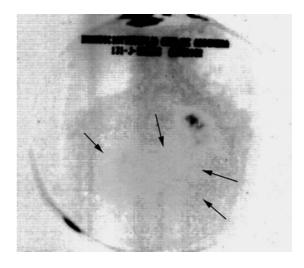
Immunoscintigraphy with IMACIS 1 anterior view shows increased accumulation of activity under the lower edge of the liver – peritoneal carcinosis.
